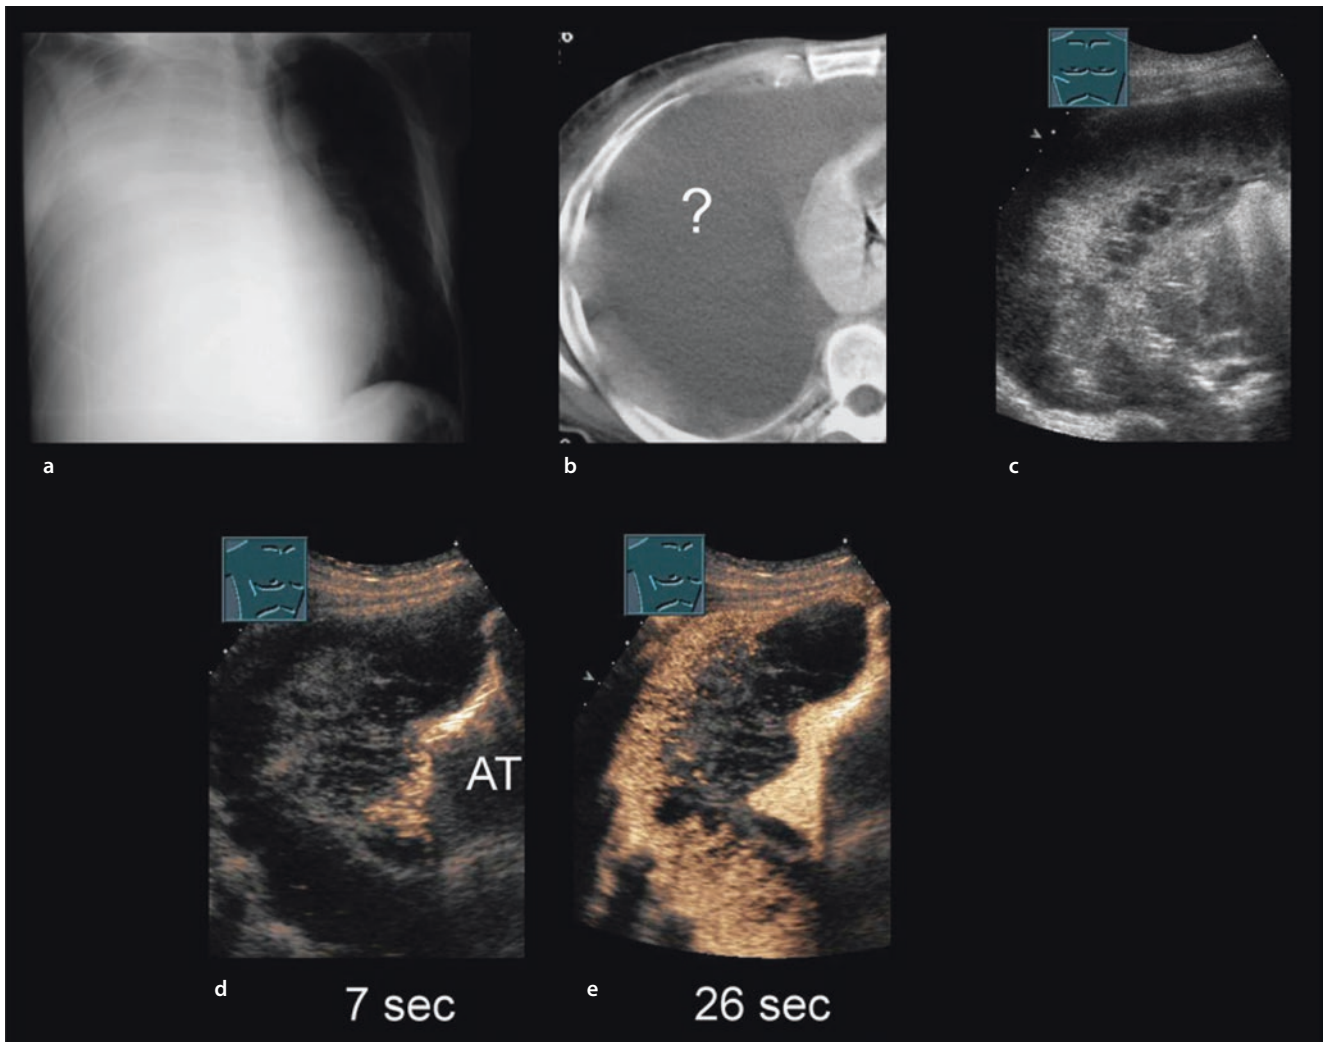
Man with a known malignant melanoma. a The chest X-ray shows complete shadowing of the right half of the chest. b Solid portions cannot be clearly reliably identified in the effusion on CT. c The B-mode image shows a hemithorax with multiple septa. d Contrast-assisted
